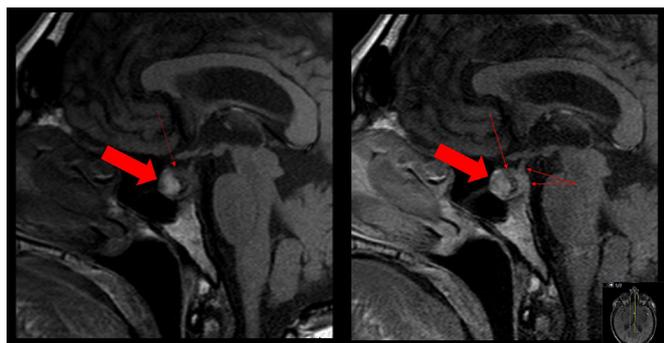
Unenhanced (left) and contrast-enhanced (right) T1-weighted sagittal MRI scans demonstrate an area of high signal within the enlarged pituitary gland due to methaemoglobin (large arrow) and a smaller crescentic area of the haematoma at a different stage of evolution (small arrow). There is normal enhancement of the compressed pituitary tissue and pituitary stalk (paired arrows right image).
